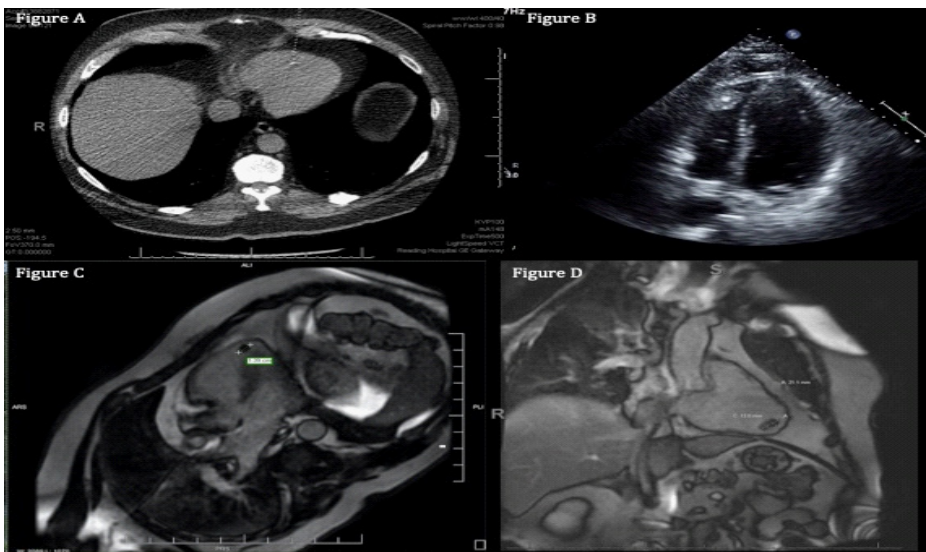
Figure legends for Right ventricular myxoma: an incidental finding on CT chest lung screen.
